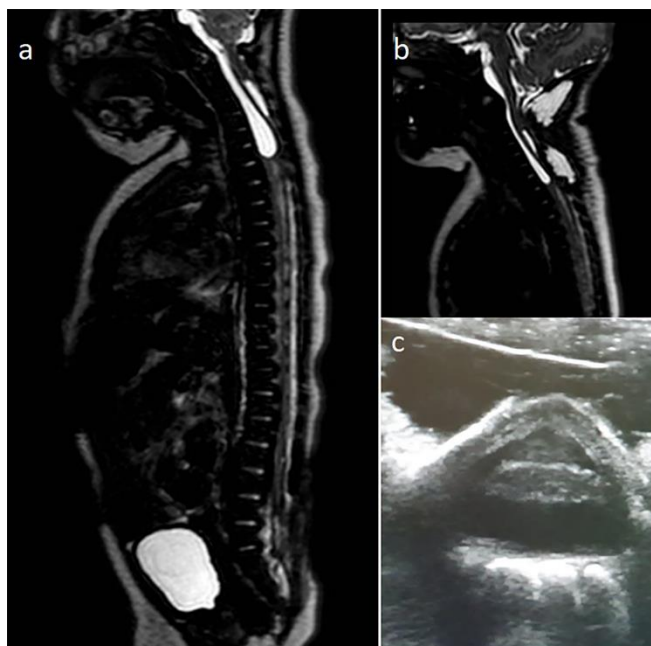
a) Sagittal T2-weighted FIESTA MRI sequence showing a cervical arachnoid cyst ventrally to the spinal cord causing a mass effect and dorsal displacement of the cord; b) On postoperative sagittal T2-weighted FIESTA MRI of the spine a reduced cyst size can be observed; c) Intraoperative ultrasound image showing the bone signal, the spinal cord and the anterior space with the arachnoid cyst.
